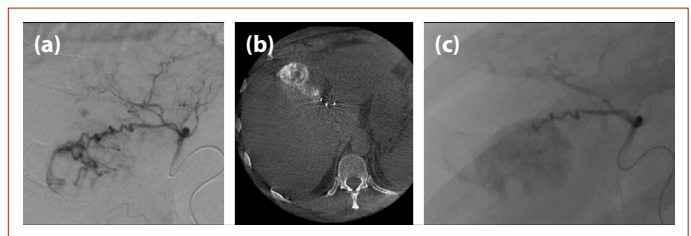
Superselective catheterization of the tumor feeding arterial branch of segment IV artery shows slight active contrast extravasation from the periphery of the tumor (a). Cone-beam CT slice (b) shows the hypervascular tumor. After selective bland embolization with calibrated particles selective angiography image (c) demonstrates retained contrast in the tumor and cessation of active contrast extravasation.
